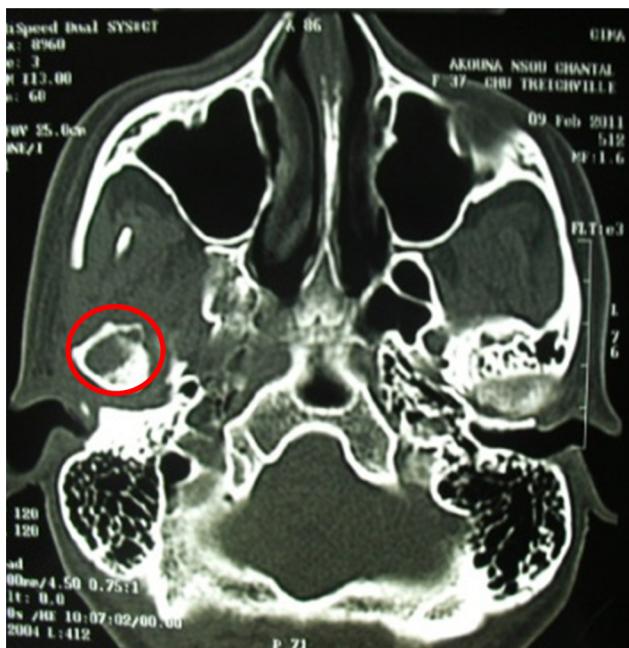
Axial CT-Scan showing intra-articular lacunae of the right mandibular condyle (circle).
